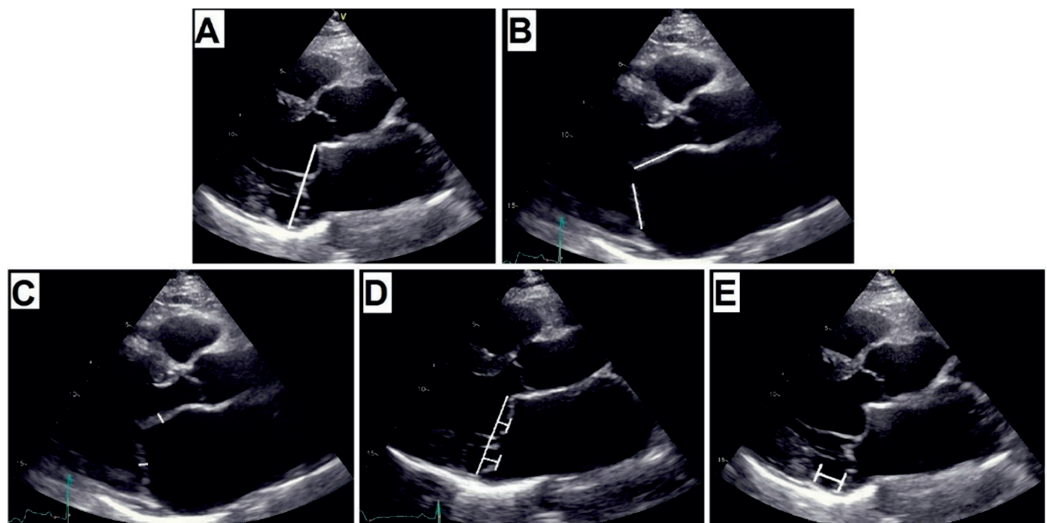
Transthoracic echocardiography showing the specific mitral valve measurements: (A) mitral annular diameter (B) Length of mitral valve leaflets (C) Thickness of mitral valve leaflets (D) Billowing height of mitral valve leaflets (E) Mitral annular disjunction
